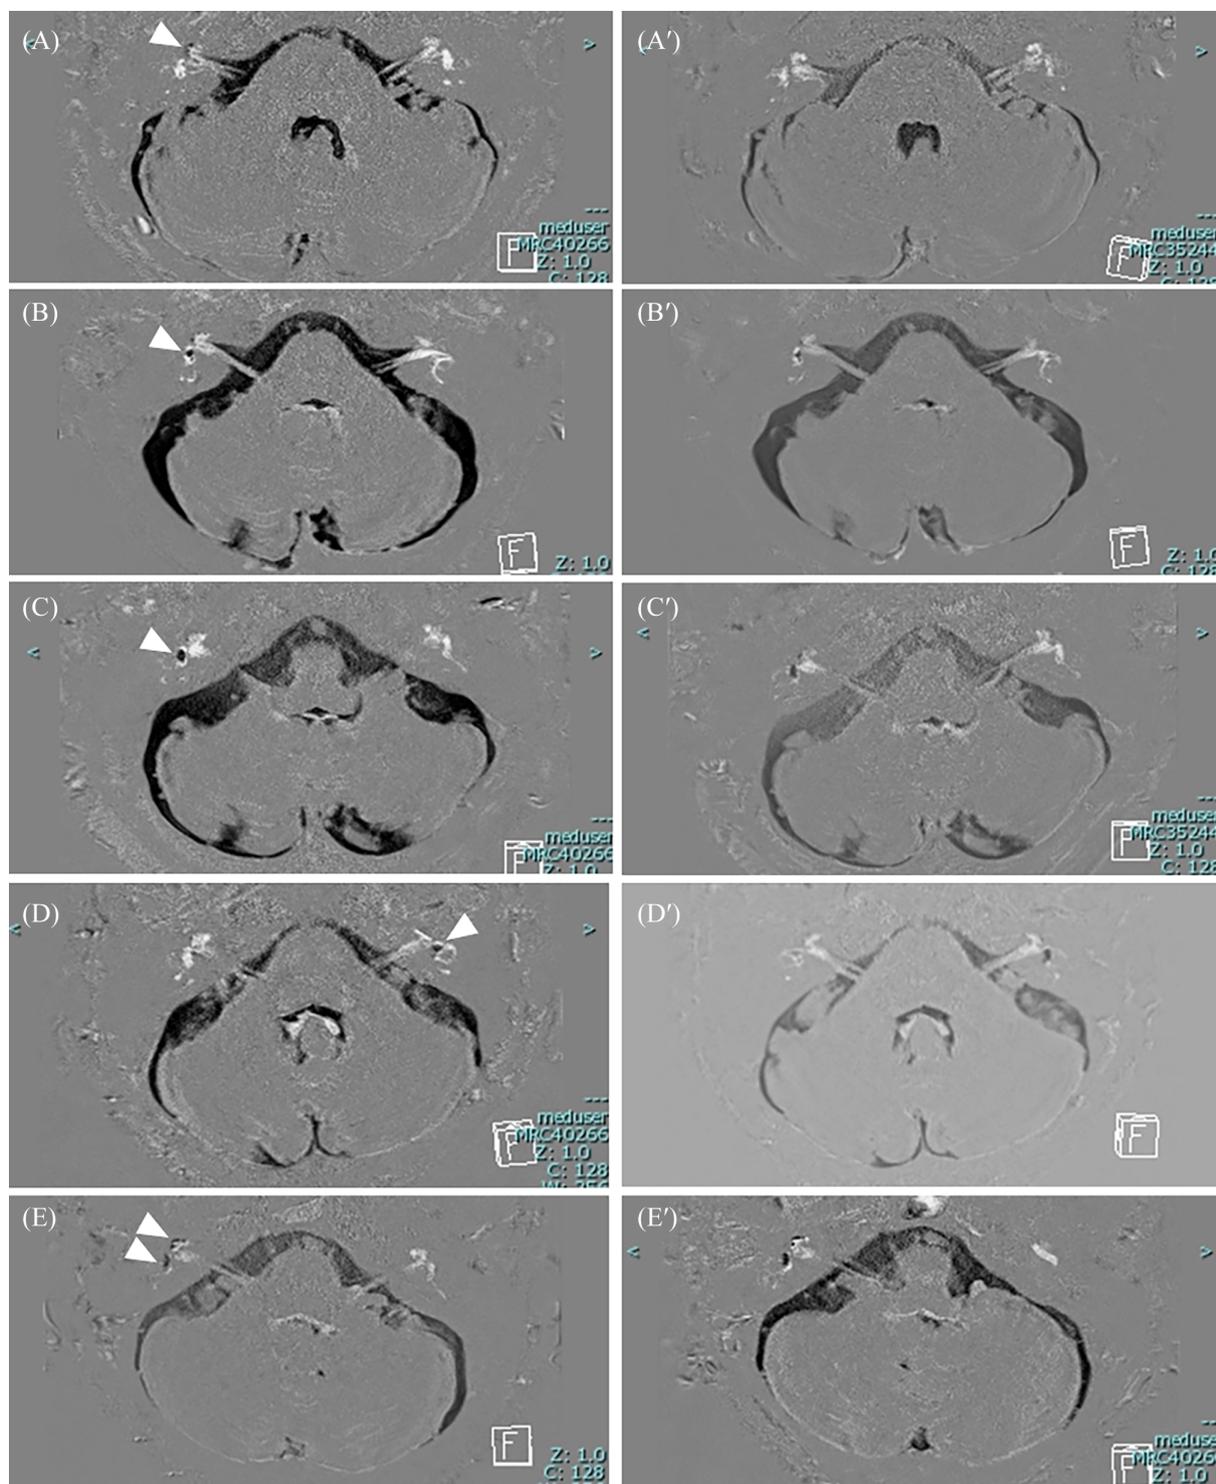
Representative participants with asymptomatic endolymphatic hydrops (EH) at the first inner ear magnetic resonance imaging (MRI) (A–E) and changes in the EH at the second inner ear MRI (A'–E'). Compared with the inner ear defects of 8 participants with asymptomatic EHs on the first MRI (A–E), EH almost disappeared in participants A' (Case-1 in Tables 1 and 2) and B' (Case-4 in Tables 1 and 2) 5 years later. EH persisted in participants C' (case-5 in Tables 1 and 2), D' (Case-7 in Tables 1 and 2), and E' (Case-8 in Tables 1 and 2) 5 years later. Participant C' showed no symptoms of Meniere's disease, but participants D' and E' developed typical symptoms of Meniere's disease. White arrowheads indicated EH in figures at the first inner ear MRI.
